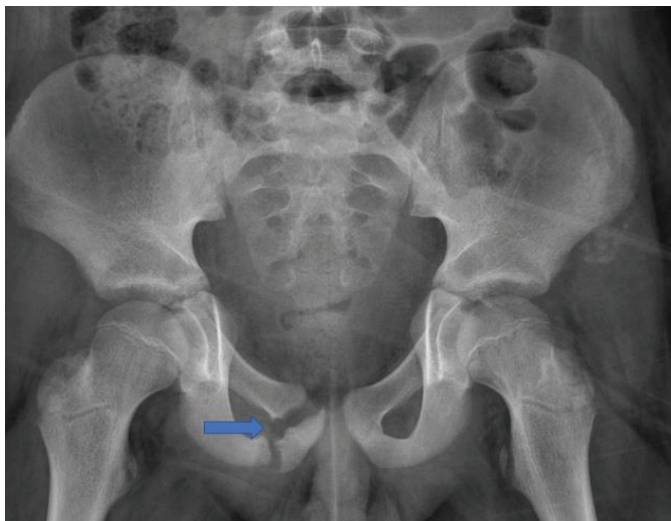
A plain radiograph showing of the superior and inferior right pubic ramus fracture (arrow)
